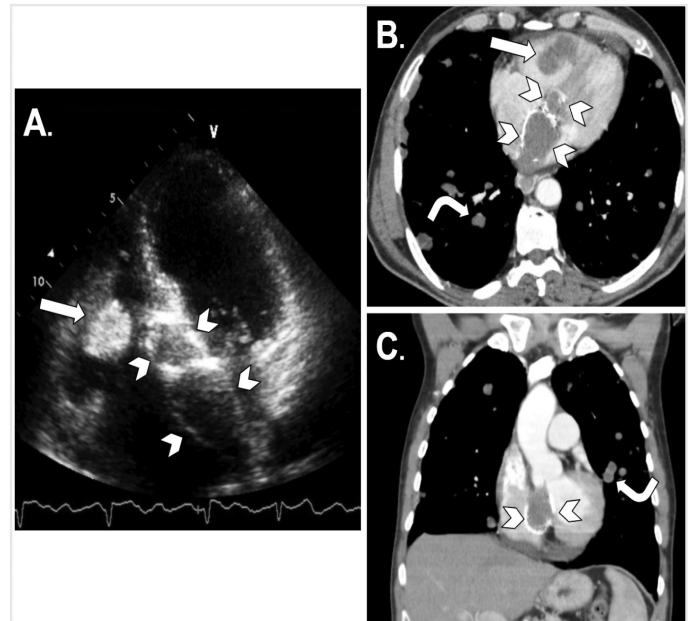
(Patient 3*) A 63 year-old male patient with two cardiac hydatid cysts: one Gharbi type 4 and one type 5. The right intraventricular cyst is hyperechoic on TTE (arrow, A) and hypodense on CT (arrow, B). The interventricular septum cyst is hypoechoic and has hyperechoic peripheral calcification (arrowheads, A). The interventricular septum cyst is hypodense with hyperdense peripheral calcification on axial (arrowheads, B) and coronal (arrowheads, C) CT images. Pulmonary hydatid cysts are also seen on axial (curved arrow, B) and coronal (curved arrow, C) CT images
